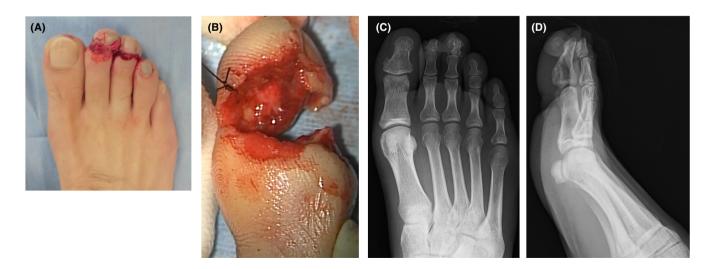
Initial presentation. (A) Incomplete crush amputation at the base of the nail. (B) Lateral visual examination showed plantar skin interruption, but still attached. (C) Initial anteroposterior radiograph of the forefoot. (D) Initial lateral radiograph of the forefoot.
